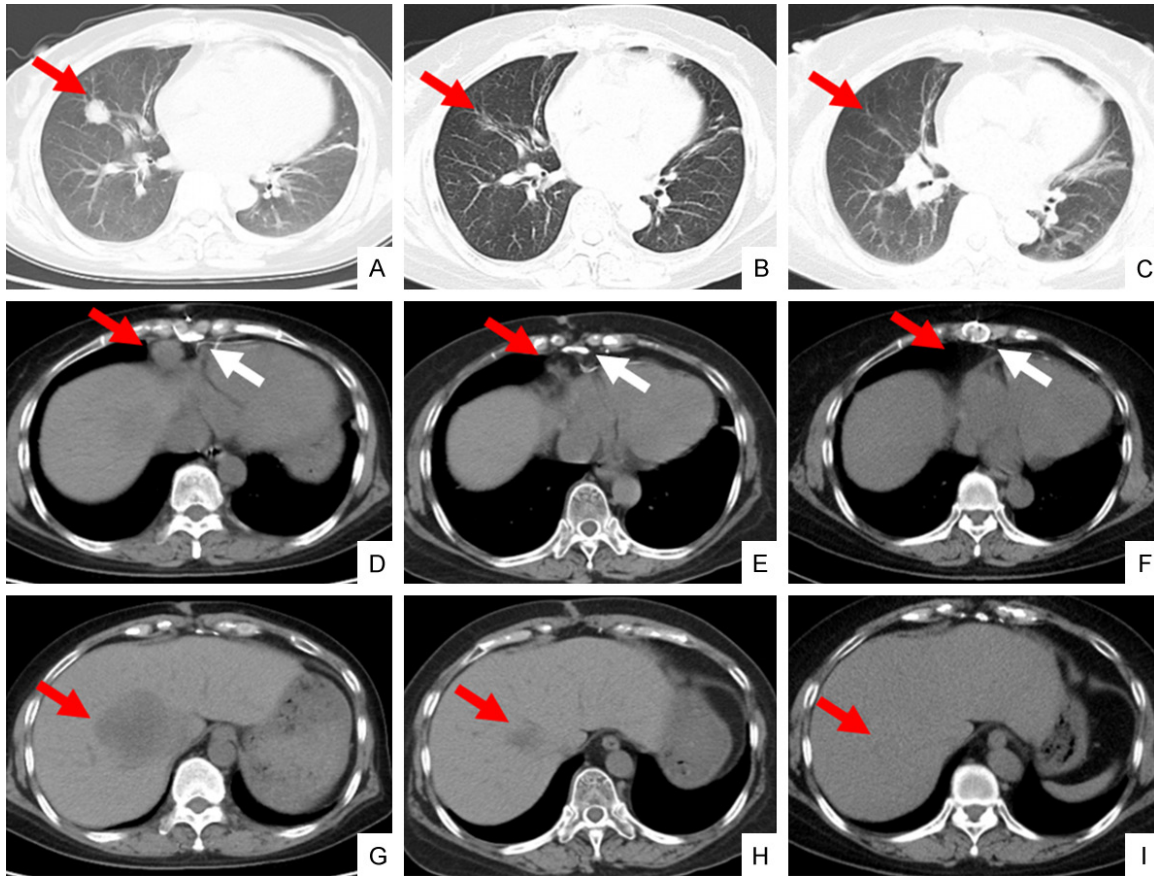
CT images of chest and abdomen before and after treatment. A. The red arrow indicated the space-occupying mass lesion; B, C. The red arrow indicated the disappearance of the space-occupying lesion after treatment; D. The red arrow indicated the enlarged lymph nodes in the heart and phrenic angle, and the white arrow indicated the postoperative imaging lesions of heart transplantation; E, F. The red arrow indicated the disappearance of enlarged lymph nodes, and the white arrow indicated postoperative changes of the sternum after heart transplantation; G. The red arrow indicated the liver mass and low-density lesions at the time of initial diagnosis (malignant tumor possible); H, I. The red arrow indicated the liver low-density lesions gradually decreased after treatment and disappear.
